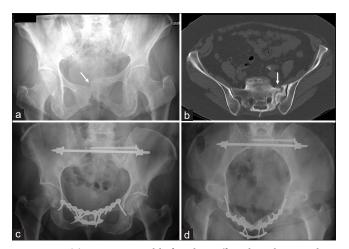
(a) A 72-year-old female suffers long-lasting deep left lumbar pain and at the symphyseal region. The pelvic AP radiograph reveals a step-off at the pubic symphysis (arrow) as sign of instability. (b) Axial CT - reconstruction shows a complete fracture of the left sacral ala with signs of sclerosis at the fracture margins (arrow). (c) Post-operative pelvic AP view. A sacral bar has been placed through the body of S1. On the left side, an additional sacroiliac screw has been inserted. The instability of the symphysis pubis has been fixed with a double-plate osteosynthesis. (d) Post-operative pelvic inlet view.
